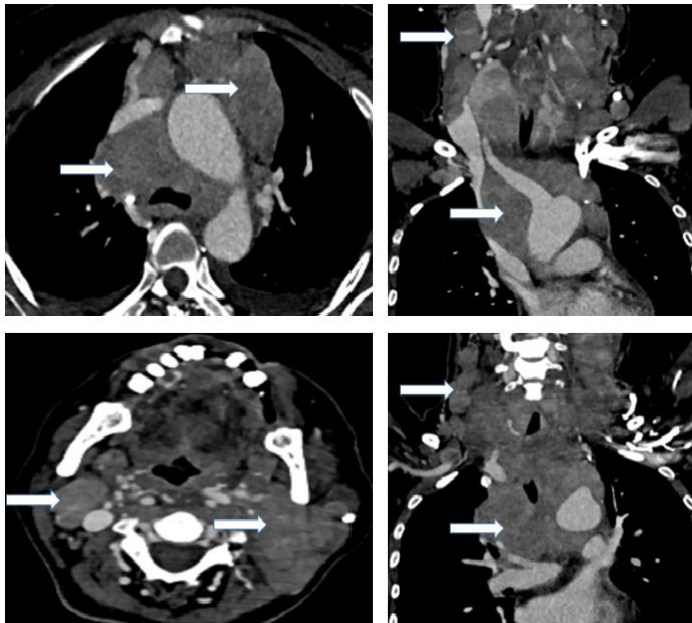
Axial contrast enhanced CT neck and upper thorax with coronal reformation in venous phase demonstrates bulky conglomerated cervical and mediastinal lymph nodes (white arrows) which insinuates between mediastinal great vessels.
